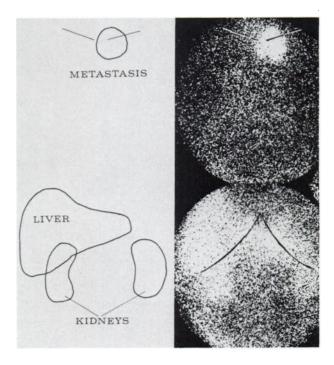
Patient with metastasis in first lumbar vertebra from anaplastic carcinoma of unknown origin. Anterior scintigrams of thoracic and abdominal regions show radioactivity in normal liver and kidneys and, unexpectedly, in left retroclavicular area. Lumbar metastasis cannot be distinguished on this anterior scintigram; patient was too ill to permit posterior scintigram.
